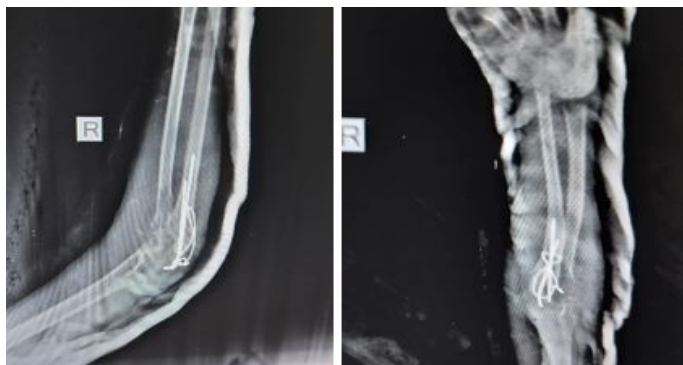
A and B- Post operative Xray, Lateral and AP view
